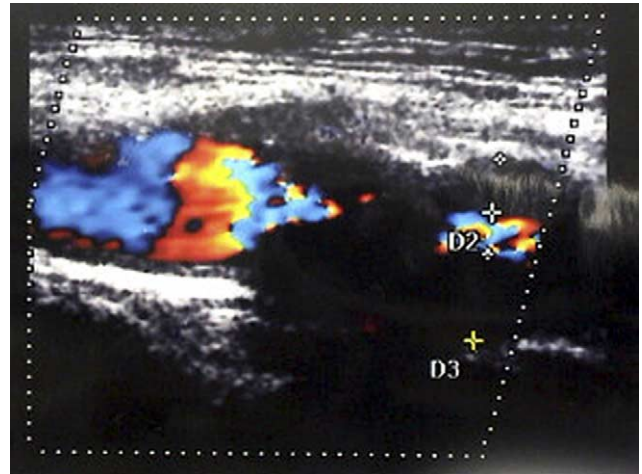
Ultrasound duplex image shows a carotid plaque and severe stenosis in a 67-year-old man. His plaque score was 9.7.
